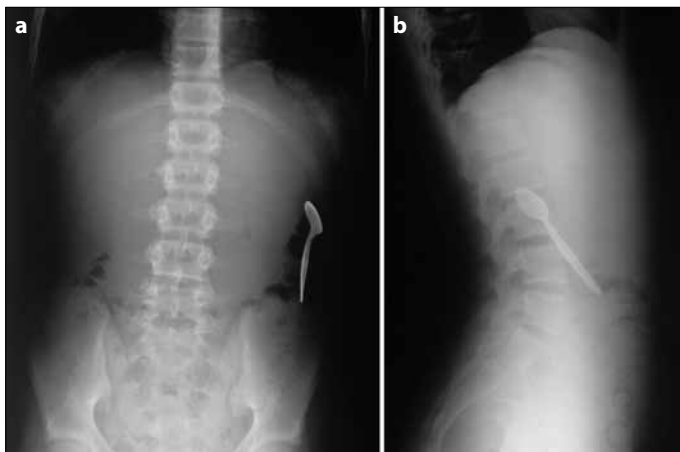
a, b. Control standing direct abdominal radiograph shows teaspoon in the left colon localization
